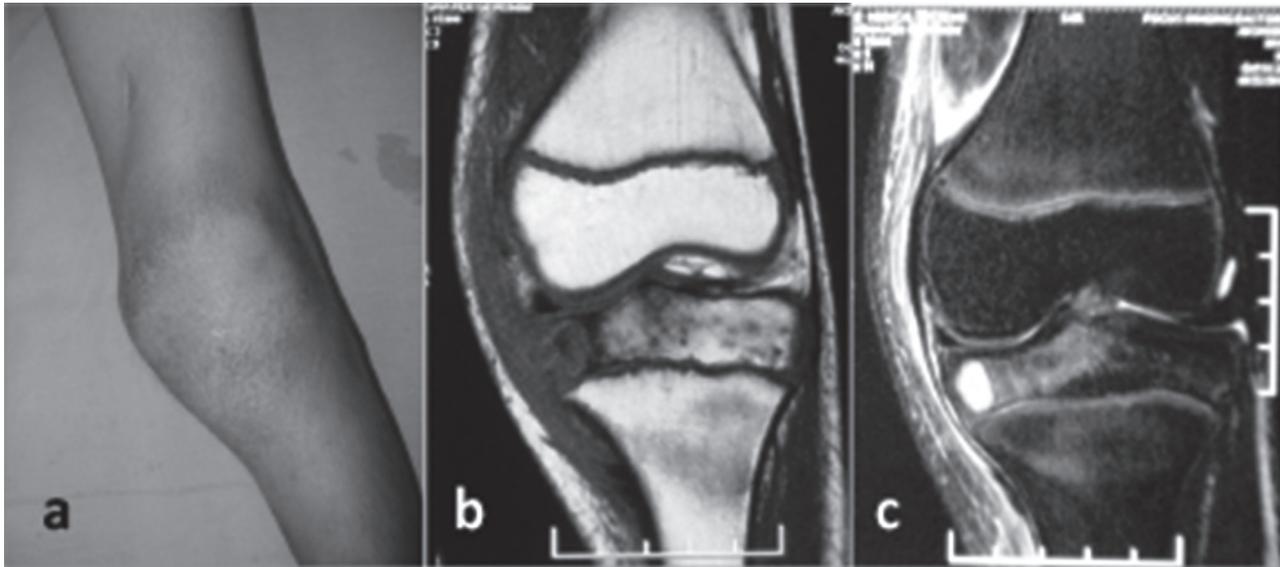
Localized epiphyseal lesion (a) Presentation with localized knee swelling and pain. Knee range of motion was fairly well maintained in this patient (b,c) MRI delineated lesion precisely and helped surgical planning [see plain radiographs (figure 2a below)]
